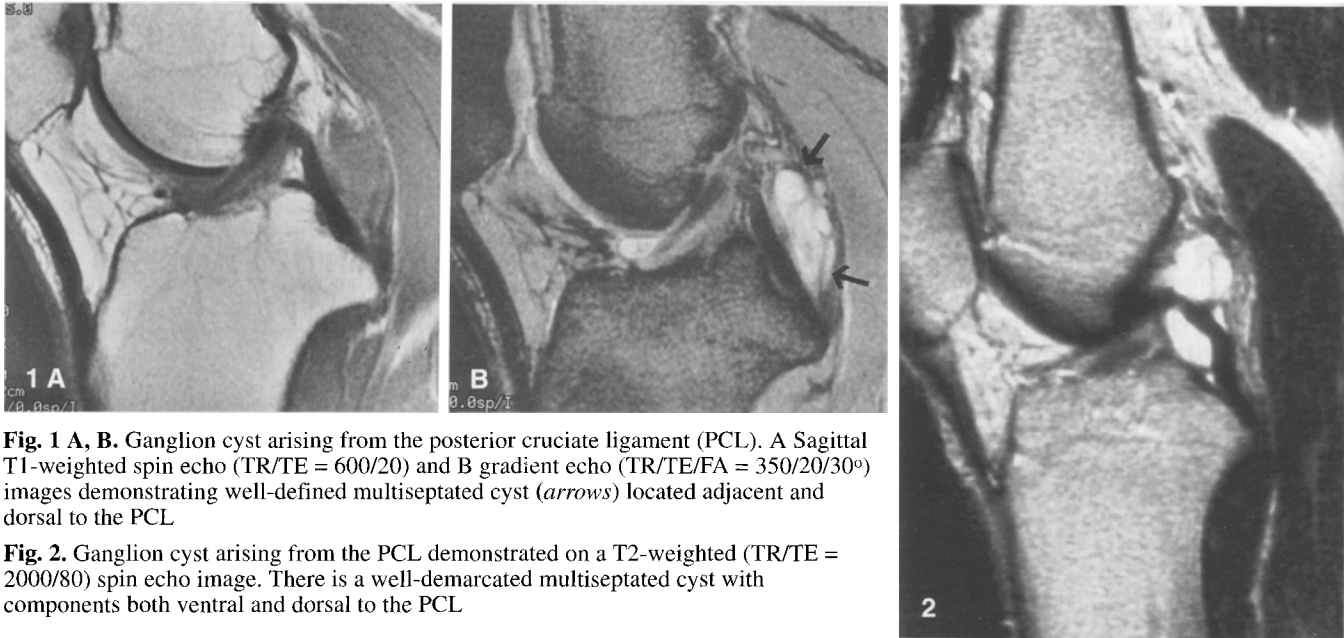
A, B. Ganglion cyst arising from the posterior cruciate ligament (PCL). A Sagittal T1-weighted spin echo (TR/TE = 600/20) and B gradient echo (TR/TE/FA = 350/20/30°) images demonstrating well-defined multiseptated cyst (*arrows*) located adjacent and dorsal to the PCL
